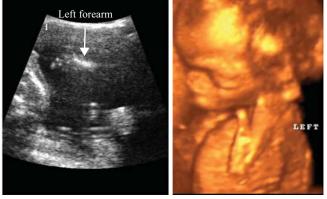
2D ultrasound (left) and 3D demonstrate superior images of anomalies.
